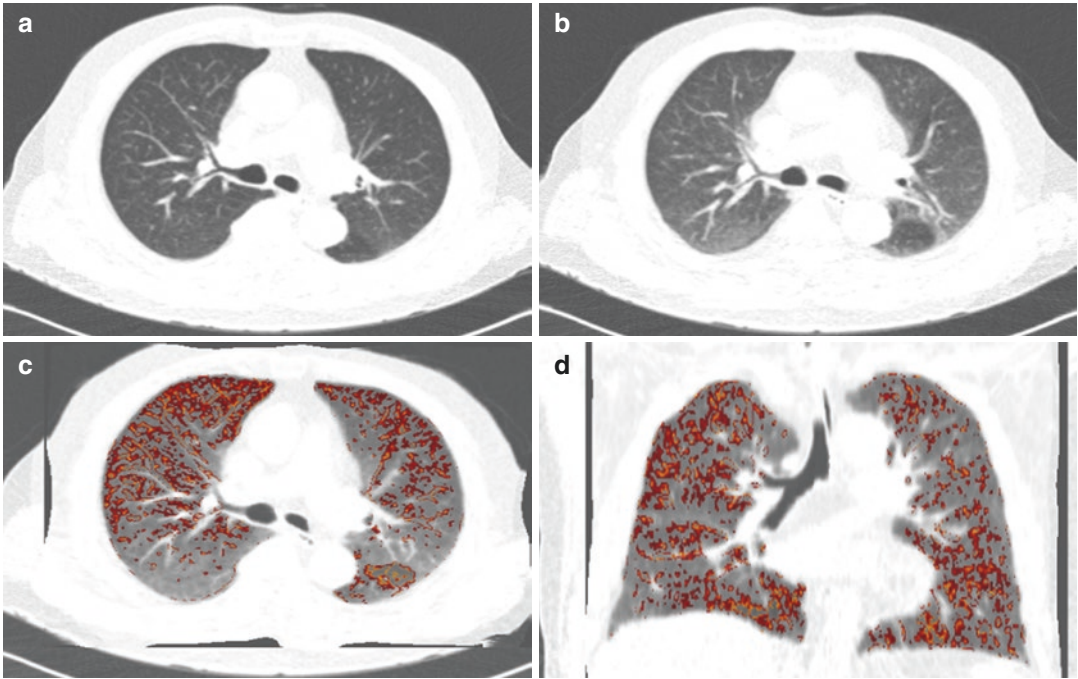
Subtraction image from co-registered inspiratory and expiratory images. Image maps (c, d) derived from co-registered inspiratory (a) and expiratory (b) images depict changes in lung attenuation from inspiration to expiration. Using image registration technique, the expiration CT image is deformed to match with the corresponding anatomical area on inspiration CT (c). By
